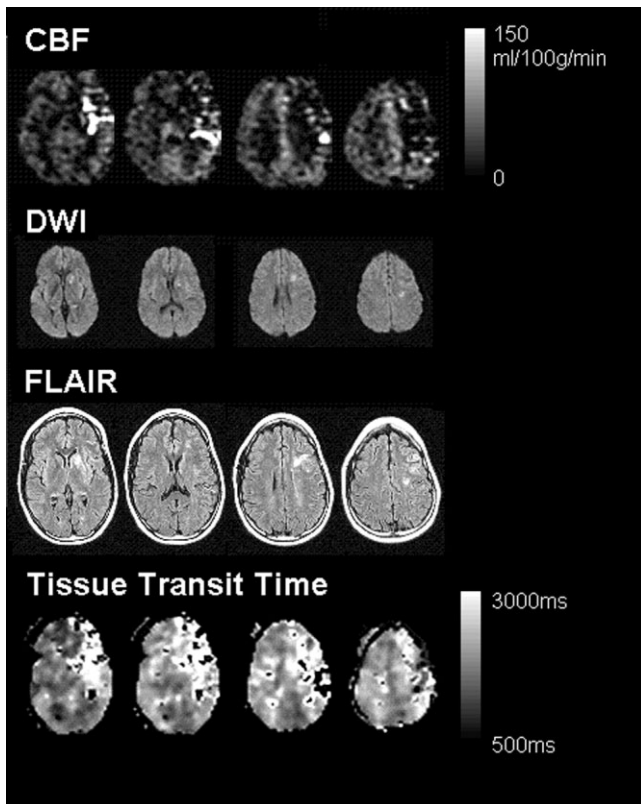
30-year-old female patient images including CBF, diffusion weighted (DWI),  $T_2$ -weighted (FLAIR), and FEAST tissue transit time images.
